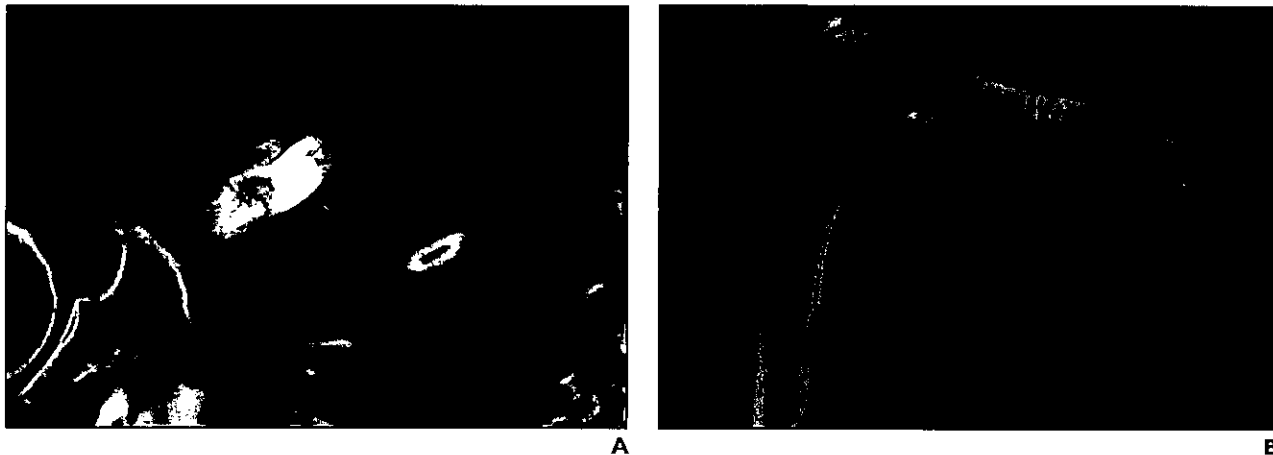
13-year-old boy with right mid-diaphyseal femur fracture after motor vehicle collision. CT was requested in immediate postoperative period to assess hardware position relative to fracture and its relationship to soft tissues, although detection of complications in immediate perioperative period is often fulfilled with radiography. A, Axial CT image from immediate postoperative examination is limited because of streak artifact. Fracture line is difficult to visualize in axial plane. B, Coronal 3D CT image shows intramedullary rod and screw fixation with good postoperative alignment. Also note fracture of posterior roof of acetabulum (arrow).
